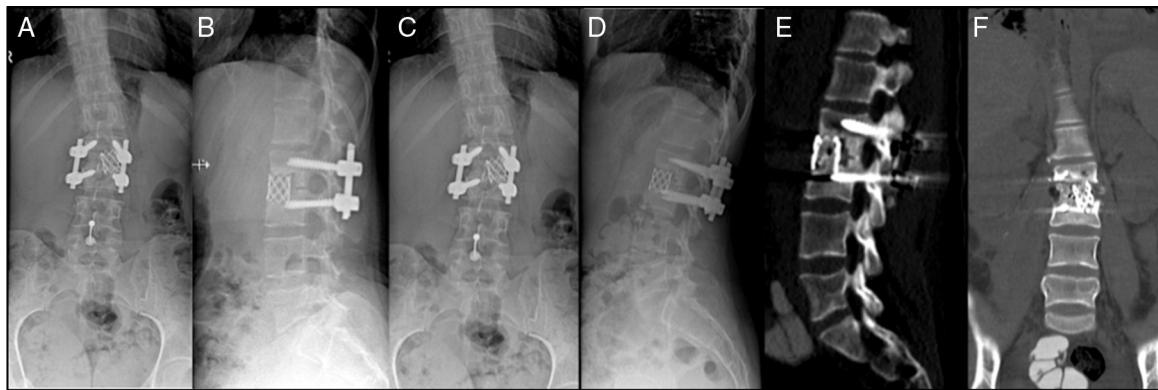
(A) and (B) Immediate postoperative control; (C) and (D) One year postoperative control; (E) and (F) CT-scan showing L2-L3 interbody arthrodesis.
